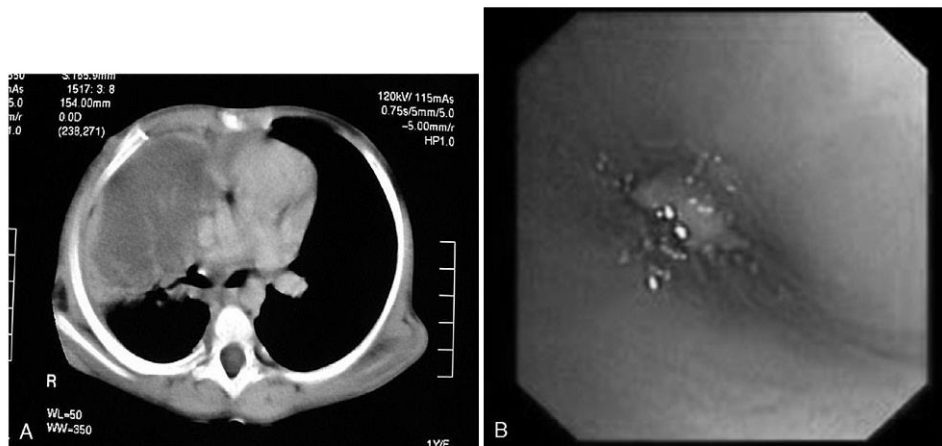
(A) Chest CT scan demonstrating homogeneous opacification of right upper lobe. In the opacified lobe, extensive areas of liquefaction are visible. (B) The right upper lobe bronchus is also obstructed.
